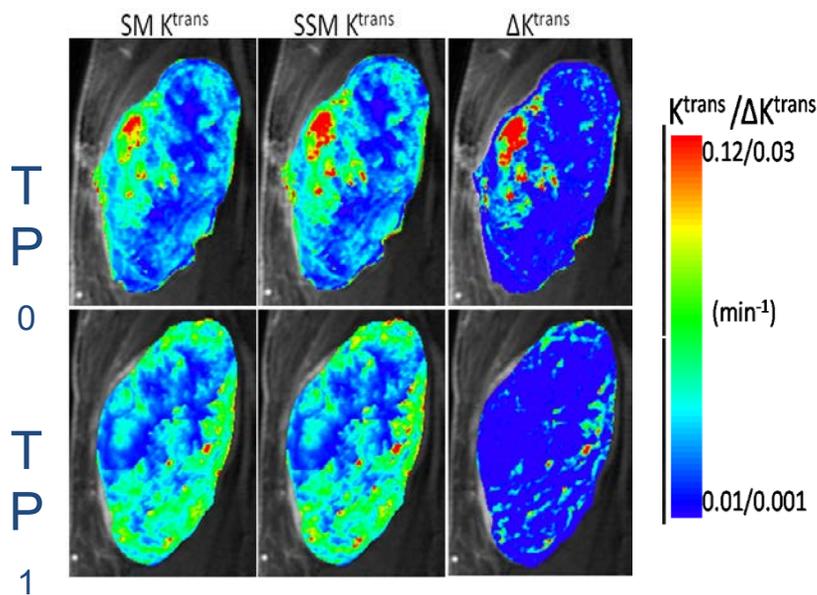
Myxoid round cell liposarcoma of thigh demonstrating change in 3 different DCE-MRI biomarkers ($SM K^{\text{trans}}$, $SSM K^{\text{trans}}$, and ΔK^{trans}) from baseline (TP_0) to 2 weeks after sorafenib treatment (TP_1)
